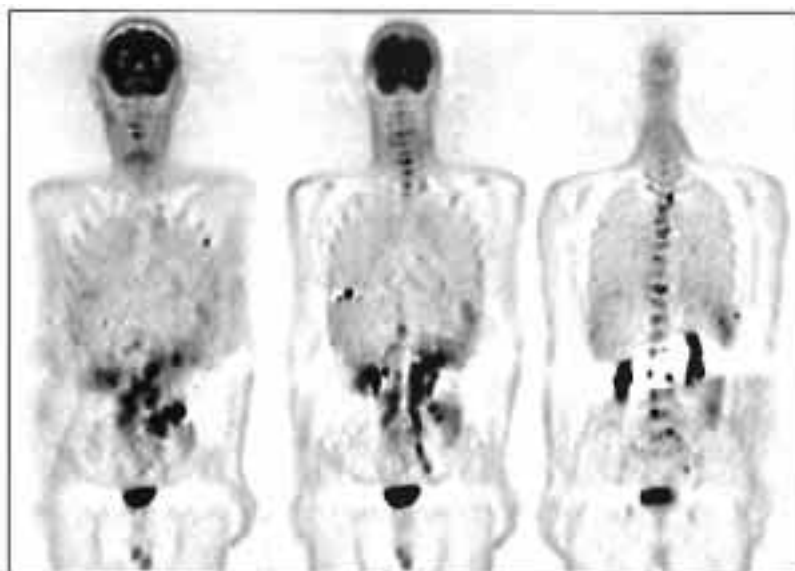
A 43-year-old male patient with extensive, intermediate-grade NHL. FDG-PET demonstrated abnormally high uptakes in the abdominal para-aortic, parailiac and mesenteric regions and spleen. Multiple bone marrow involvement is also demonstrated in the spine and ribs.
